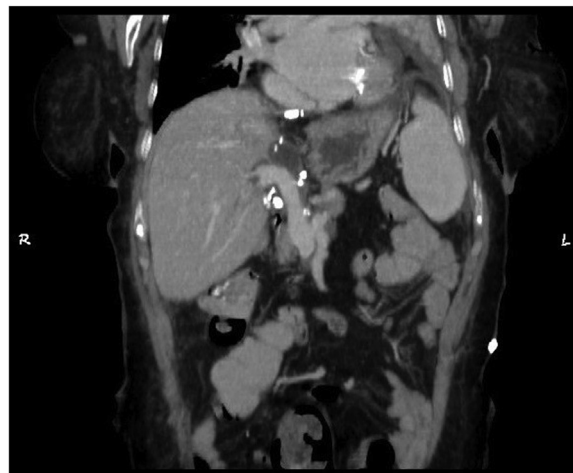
Computed tomography demonstrating patent portal vein 40 days after transplant.
